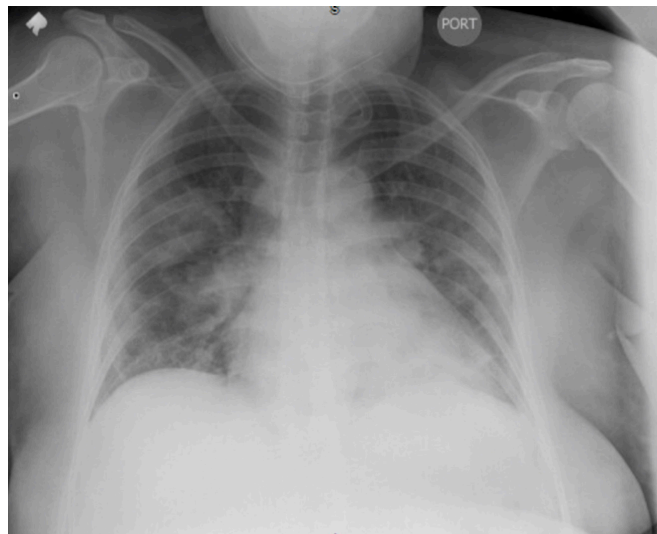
Chest X-ray on hospital day 1 with patchy airspace opacities in the middle and lower lung fields.
